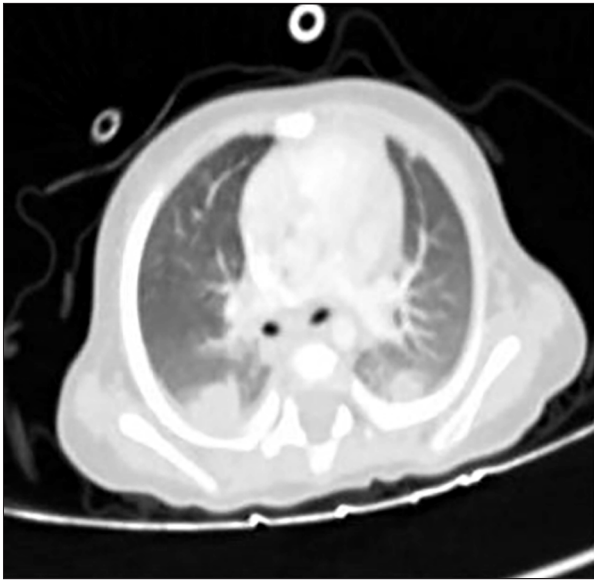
Lung computed tomography shows multiple metastatic lung nodules.
